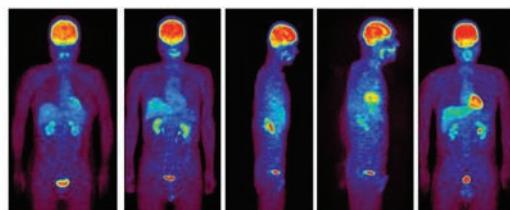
Whole body PET images 1 hour after intravenous administration of $\text{F}-18\text{ fluoro-deoxy-glucose (FDG)}$ in five different normal volunteers. All subjects showed high FDG uptake to their brain. Myocardial uptake was found when blood glucose level was high. FDG is excreted from urinary system.
